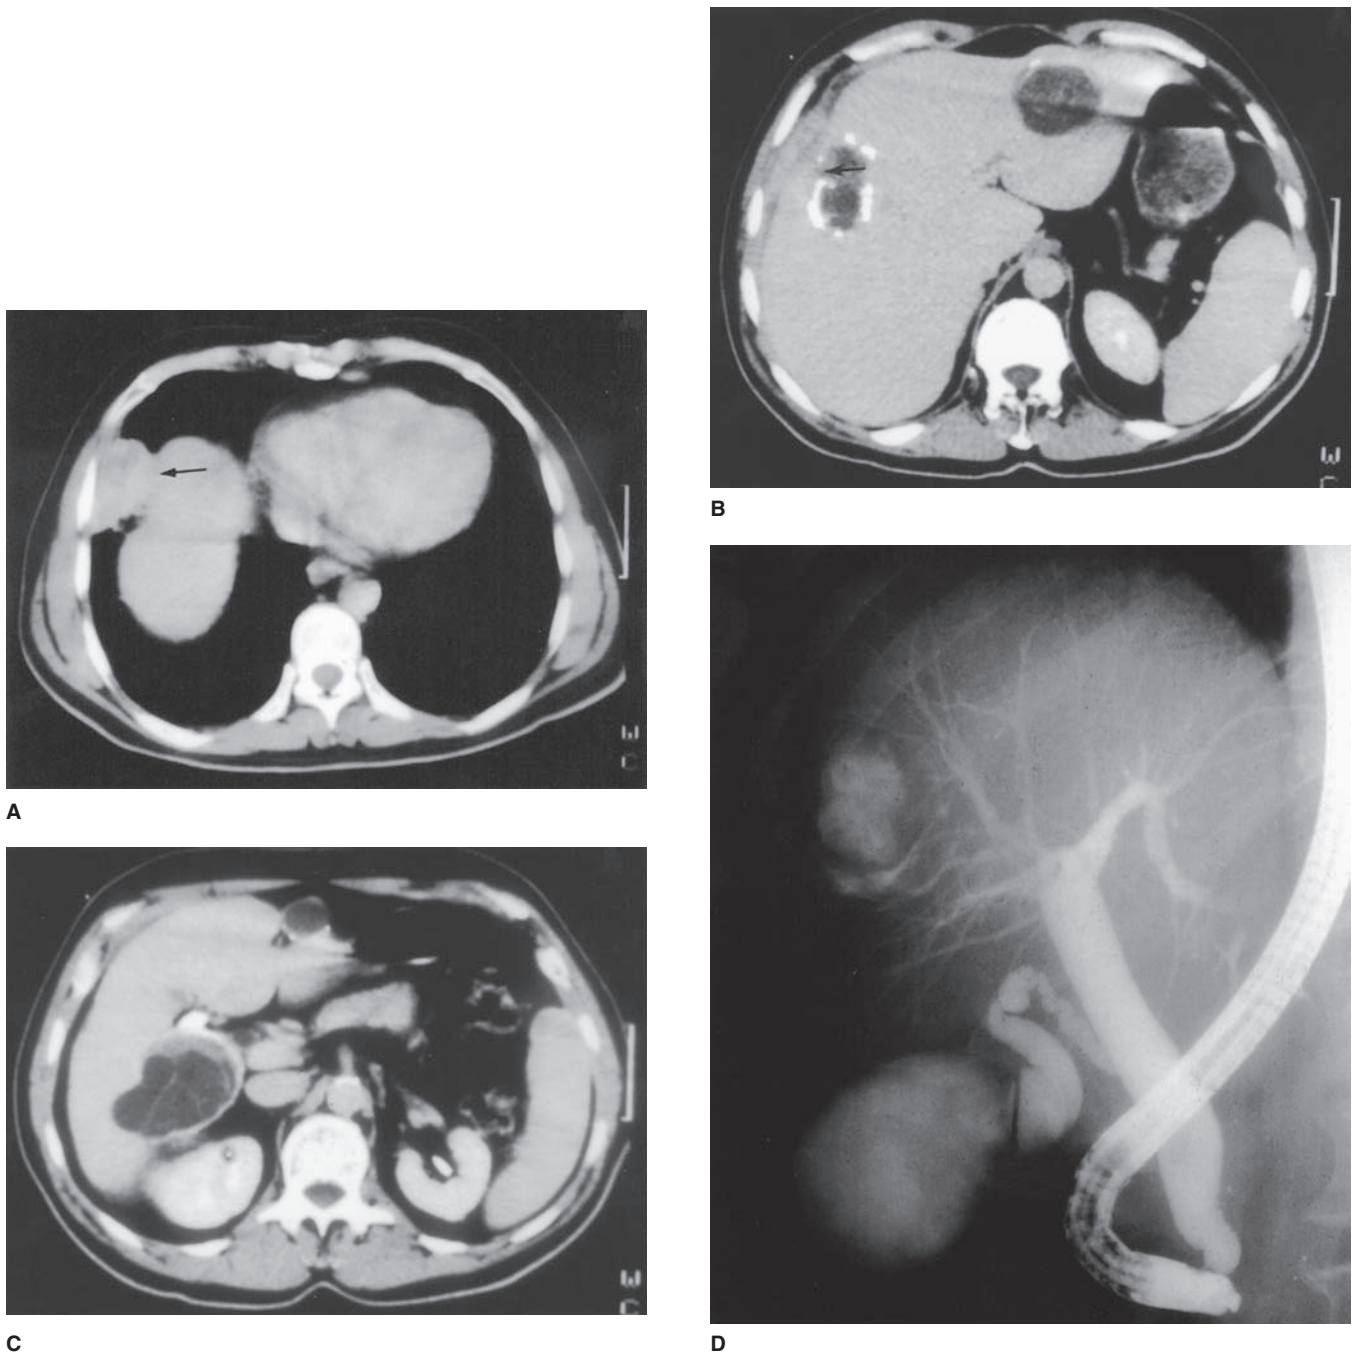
A. CT scan demonstrating rupture of hydatid cyst through the diaphragm (*arrow*) into the pleural space. B. CT scan in the same patient demonstrating a heavily calcified hydatid cyst (*arrow*) with diaphragmatic penetration and a lightly calcified cyst on the left. C. CT scan in the same patient showing a third calcified cyst near the gallbladder fossa and a small superficial fourth cyst on the left. D. Endoscopic retrograde cholangiopancreatography (ERCP) in the same patient demonstrating biliary communication in the cyst that also penetrates the diaphragm.
